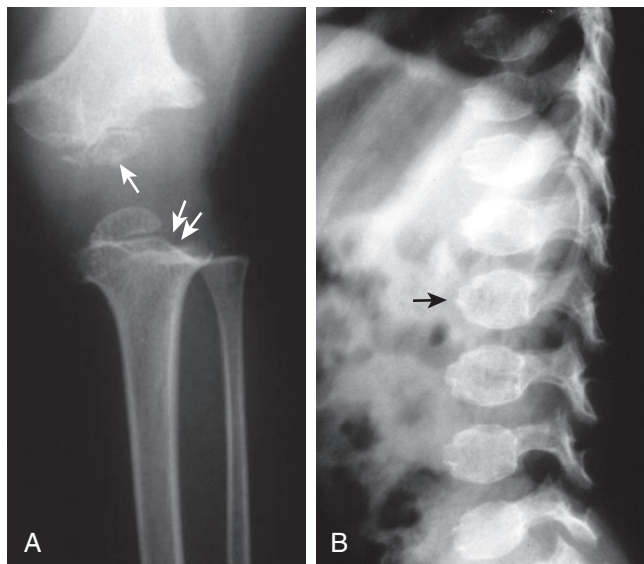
Radiographs showing abnormalities. A, Distal femur and proximal tibia and fibula showing small irregular epiphyses (*single arrow*) and irregular metaphyses (*double arrows*). B, Lateral view of the spine showing abnormally rounded vertebral bodies with anterior central beaking (*arrow*).
